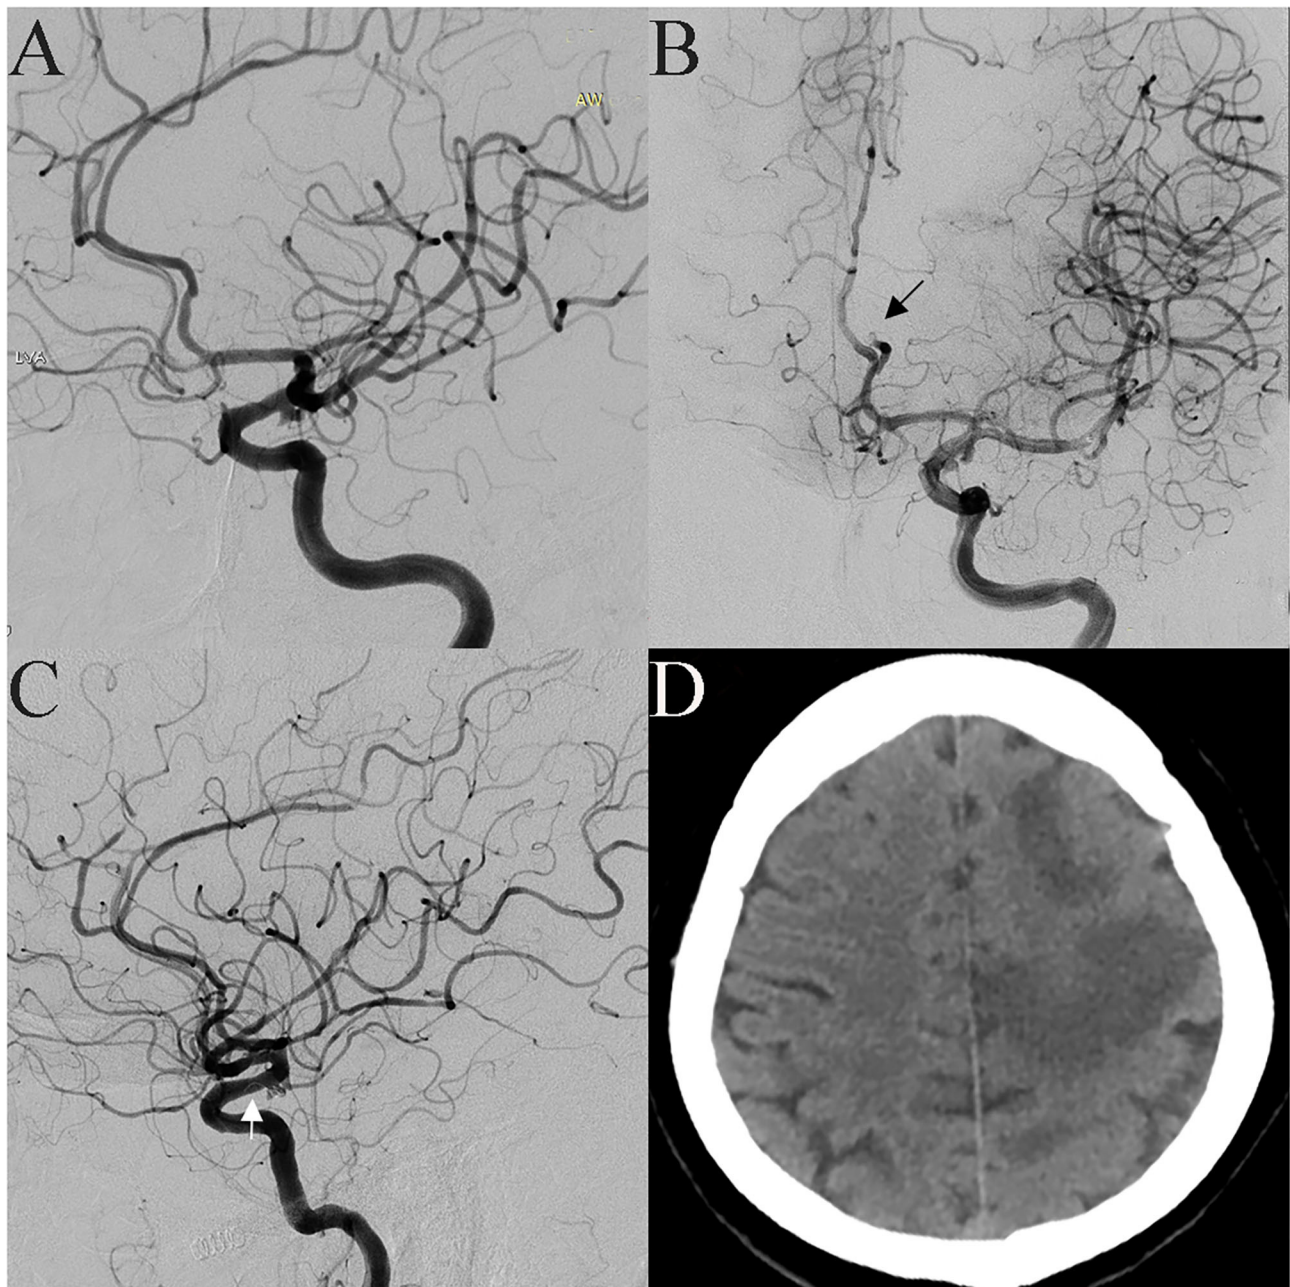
A 53-year-old female was incidentally found have a tiny aneurysm in the communicating segment of the ICA (A). Pericallosal artery occlusion was found when the microcatheter was advanced to the aneurysm cavity, and a thrombus was seen (B, black arrow). After intravascular thrombolysis, patency in the artery was partly restored. The coil prolapsed into the parent artery when the first coil was placed; therefore, an LVIS stent was implanted (C, white arrow). Postoperative CT scan showing a large infarction in the frontal parietal lobe (D).
